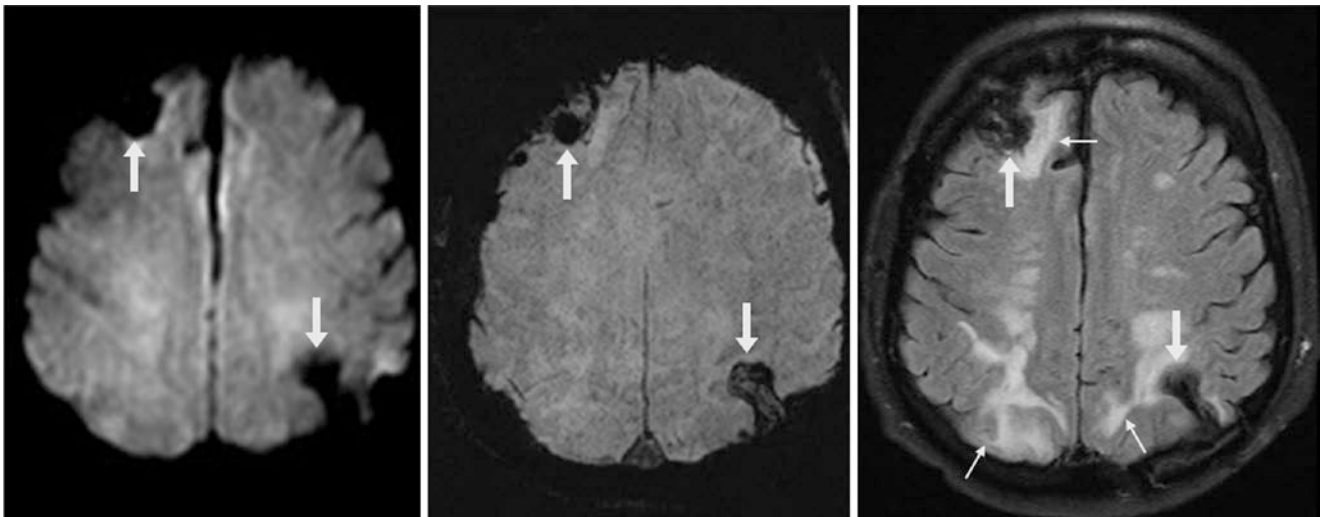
A 3 T MRI in a 58-year-old shows two foci of T2 blackout (*arrows*) in acute parenchymal hemorrhages that arose from PRES. (The patient had received chemotherapy.) These foci are dark on DWI
